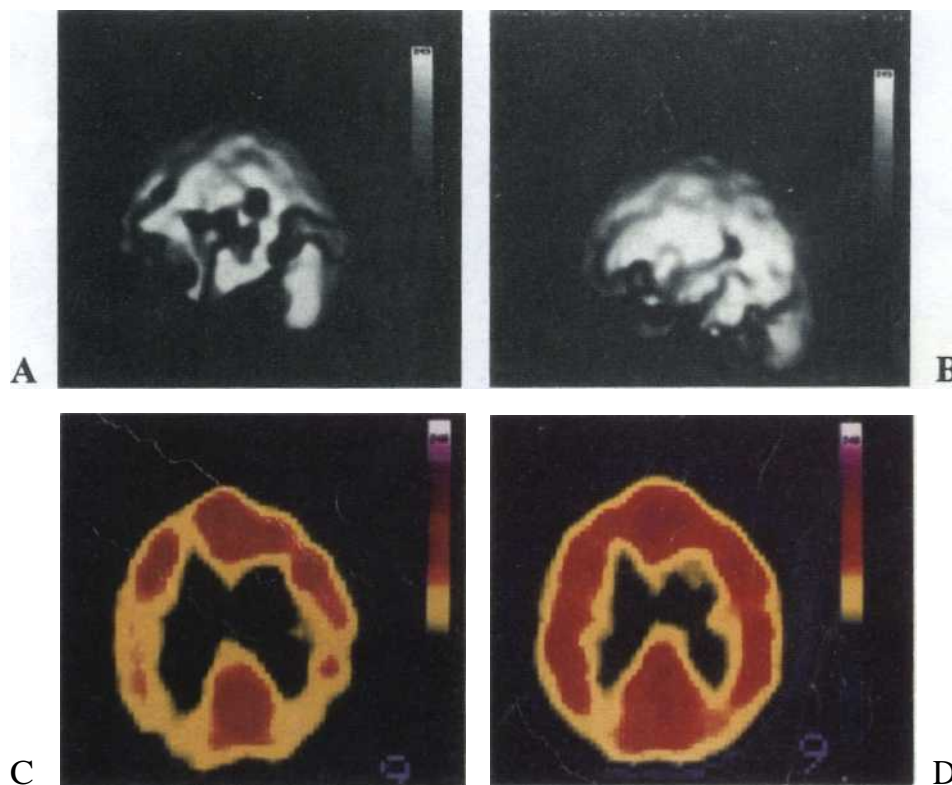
Shown are four SPECT scans of Mr. L.A.F., a 78-year-old retired school teacher from Ft. Lauderdale, Florida, who experienced the acute onset of left-sided weakness, dizziness, inability to stand, and mental confusion.
